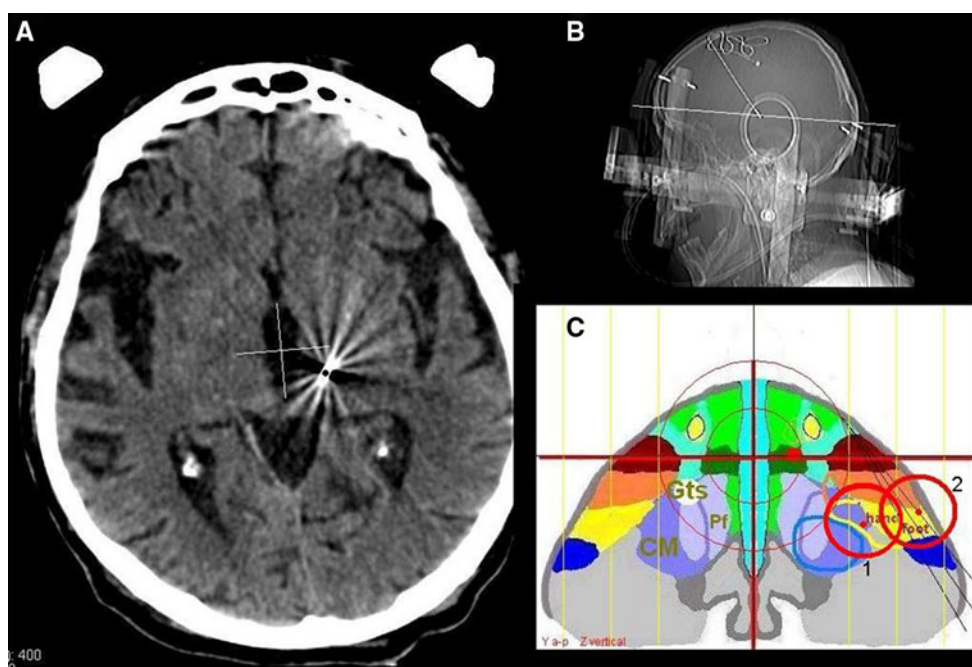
a CT scan, axial: left correct placement of DBS electrodes in the Voa/Vop thalamic complex; b skull Rx: DBS electrode after implantation and before IPGs positioning in the subclavian regions.
